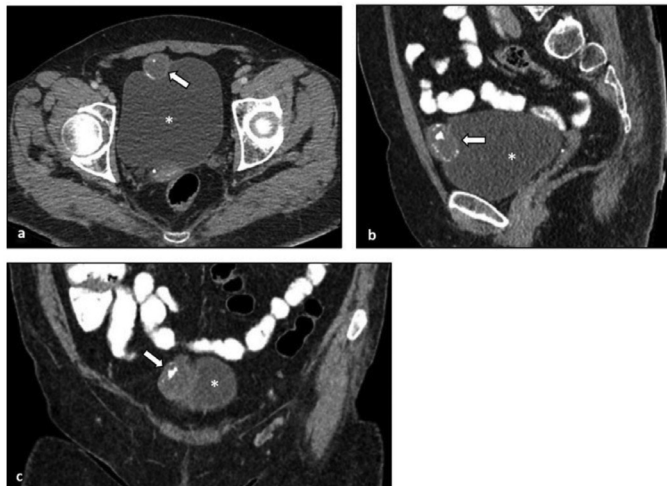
Axial (a), sagittal (b), and coronal (c) intravenous contrast-enhanced CT sections show a nodular lesion (arrows) with a diameter of approximately 30 mm, which extends toward the prevesical fat tissue and the anterior abdominal wall, contains coarse and curvilinear calcifications, and appears hypodense, most likely due to the presence of mucinous content. The lesion (*) is noted to be of similar density to the bladder
